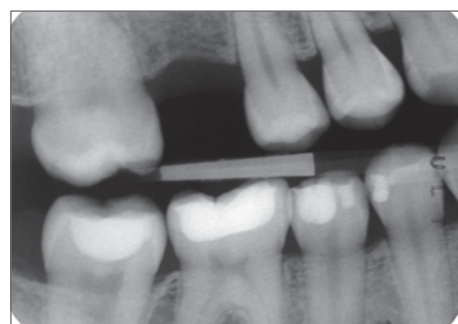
(right) Posttreatment bitewing radiograph.
